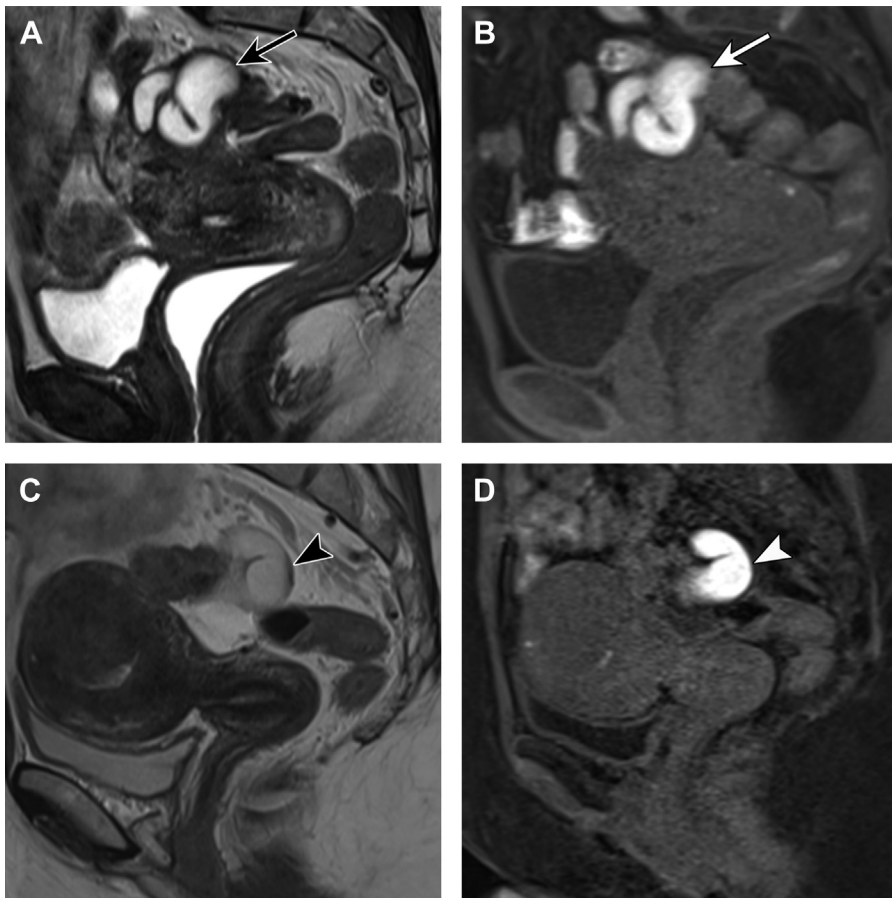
Hematosalpinx in two patients (A and B vs C and D). Sagittal T2-weighted MR image (A) shows a dilated tubular structure posterior and superior to the uterus (*black arrow*) with hyperintensity and no shading. Corresponding sagittal T1-weighted MR image with fat saturation (B) shows diffuse hyperintense signal compatible with hematosalpinx (*white arrow*). Sagittal T2-weighted MR image (C) in a different patient shows a dilated tubular structure posterior to the uterine-cervical junction which is predominantly hyperintense but with layering hypointensity posteriorly consistent with T2 shading (*black arrowhead*). Corresponding sagittal T1-weighted MR image with fat saturation (D) shows hyperintensity consistent with hematosalpinx (*white arrowhead*).
